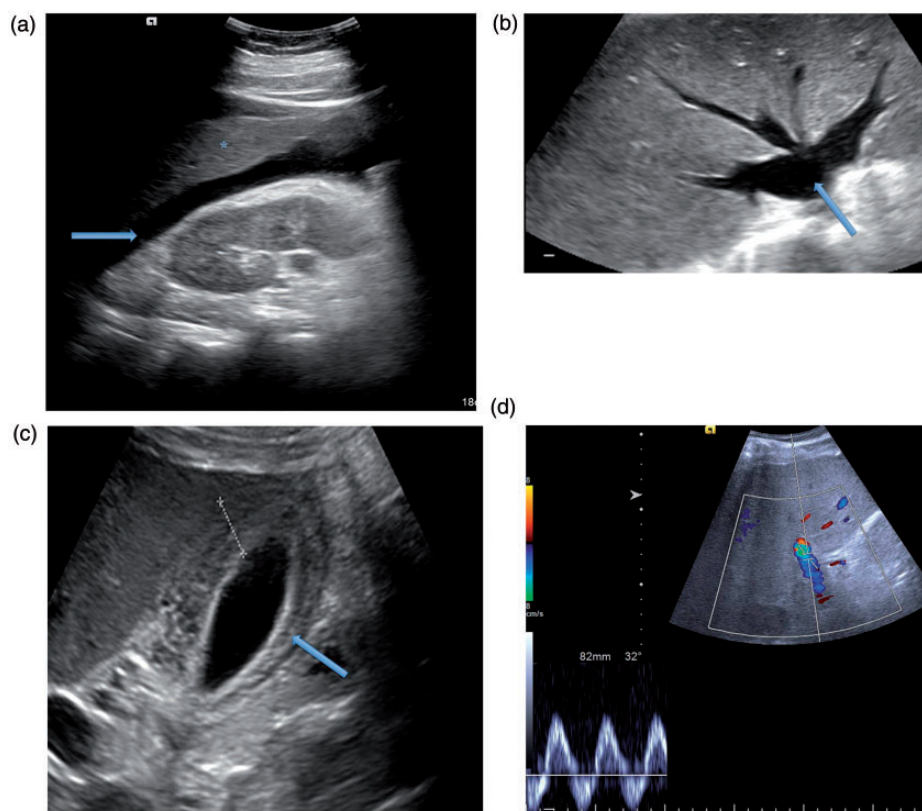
(a) An oblique section through the RUQ showing peri-hepatic simple ascites (arrow). Note the lobulated outline of the liver secondary to cardiac cirrhosis (*). (b) A transverse section through the liver demonstrating dilated hepatic veins at the confluence of the inferior vena cava (IVC) (arrow). (c) A longitudinal section through the RUQ showing a thickened, oedematous gallbladder wall (arrow). (d) A PW and colour Doppler trace taken of the portal vein demonstrates reversed and pulsatile flow.
